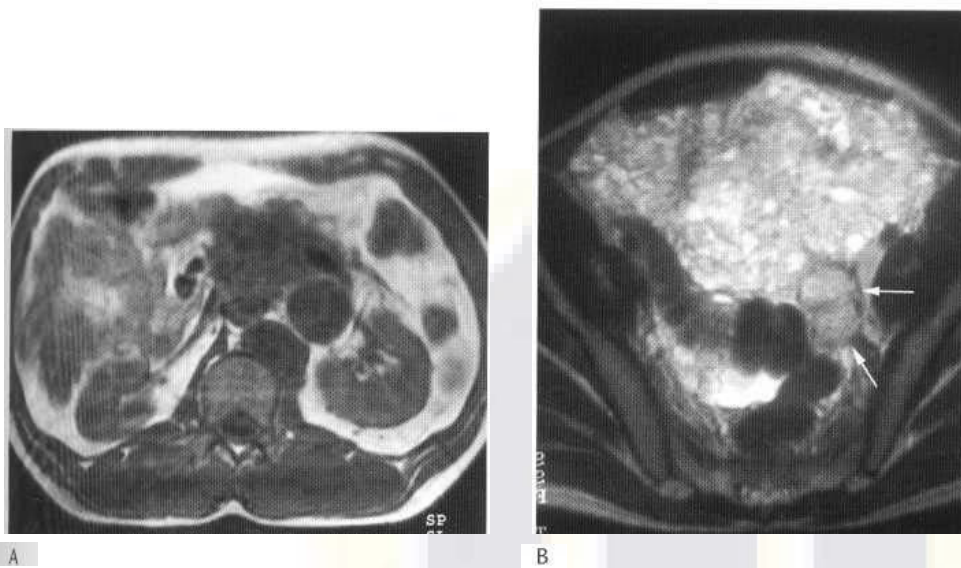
Complex deposits of NSGCT in two different patients seen on MRI. (A) In the first case there are tumour deposits in the left retrocrural area, close to the left renal hilum, and a large mass invading into the mesentery. (B) In this case an undescended testicle is the site of grossly metastatic NSGCT which is seen throughout the pelvis on this T₂-weighted image. It is interesting to note that the pattern of spread is similar to ovarian cancer because of the atypical site of the primary.
